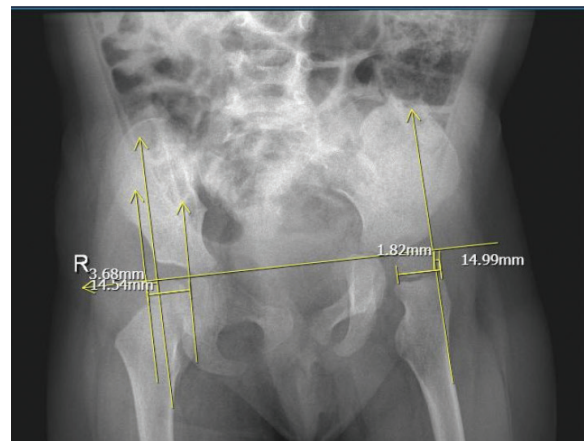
Radiograph of Pelvis.
